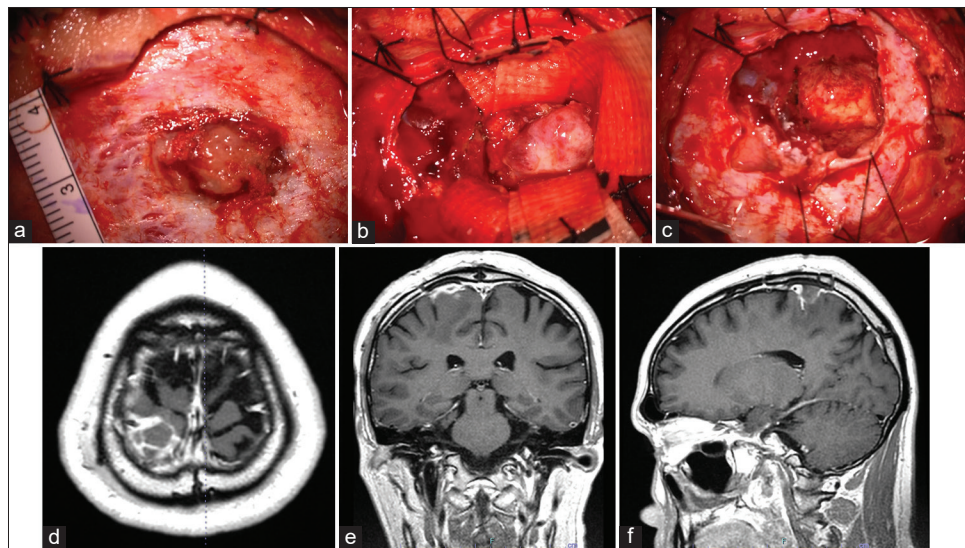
Intraoperative findings and postoperative MRI findings. During surgery, tumoral invasion beyond the dura mater was observed (a). When the dura was opened, a well-demarcated, firm, spherical tumor was observed beneath the arachnoid membrane. The tumor was elastic, hard, grayish in color, and loosely adherent to but separable from the dura mater (b). The tumor was totally removed piece by piece, with the adjacent brain tissue and dura (c). Postoperative MRI showed the total removal of the tumor (d: Axial view, e: Coronal view, f: sagittal view).
